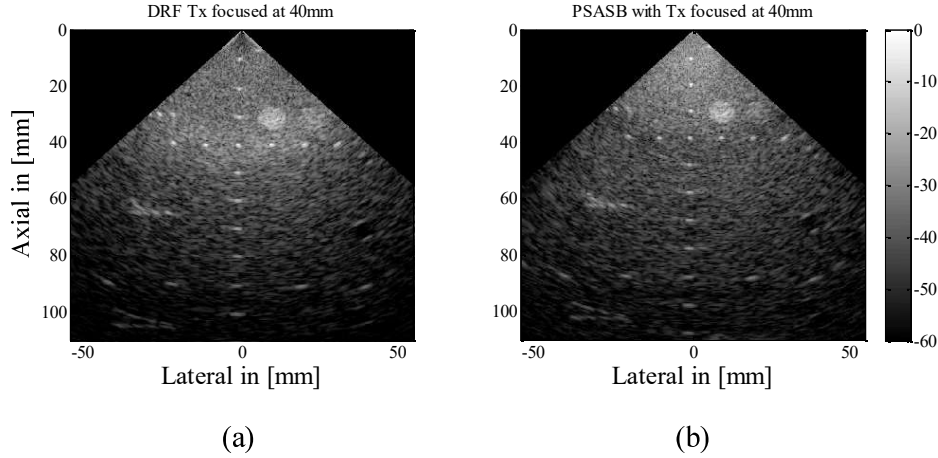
Image produced by a) Dynamic Receive Focusing and b) Phased array synthetic aperture sequential beamforming using a P4-1 phased array probe with a Verasonics Vantage ultrasound scanner. For both the cases transmit focus was at 40mm.
